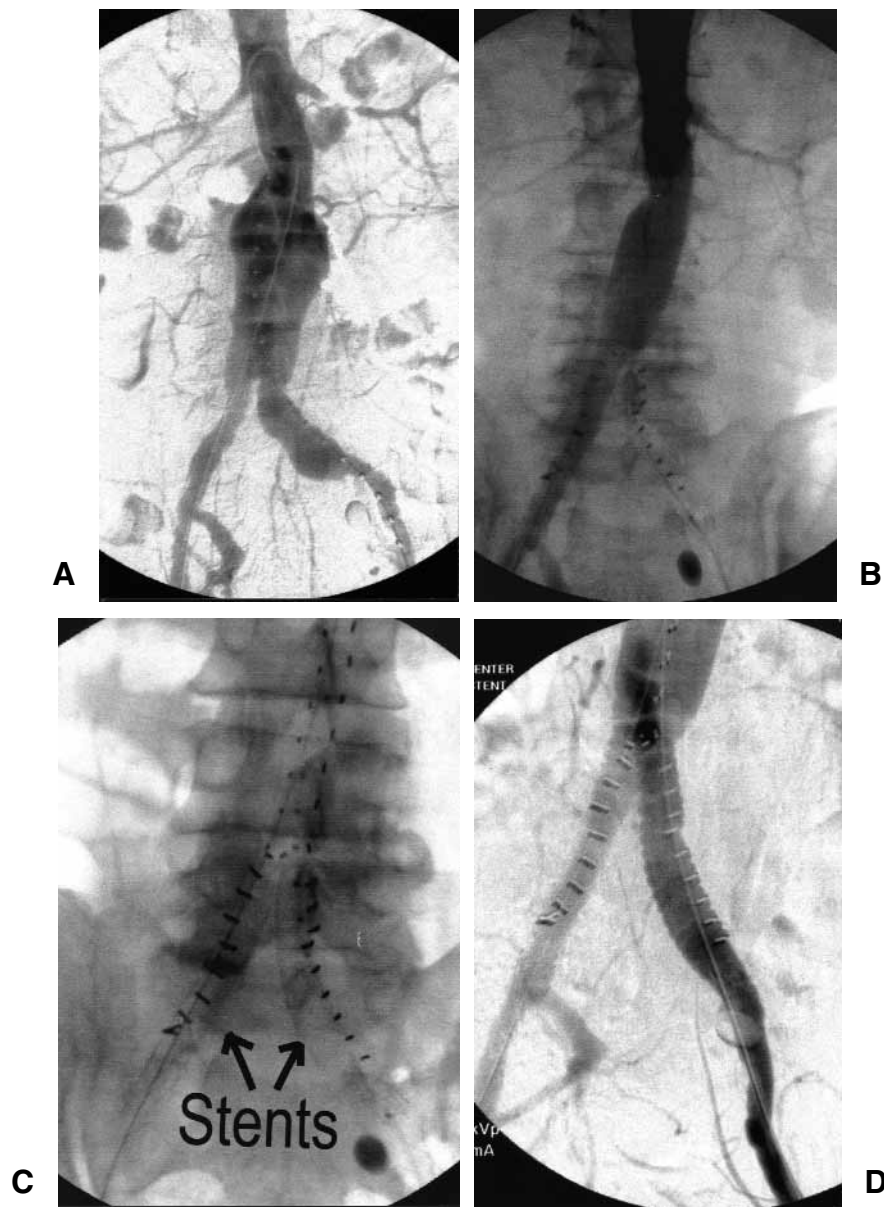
Assisted primary patency with stenting of unsupported graft limbs intraoperatively. A, Intraoperative arteriogram performed with a marker catheter (1-cm calibrations) before unsupported graft deployment shows the aortic and left common iliac artery aneurysms. After uneventful graft deployment, a completion arteriogram (B) shows no flow into the left limb of the bifurcated graft (note presence of embolization balloon previously placed in left hypogastric artery). Placement of a Wallstent (14 × 40 mm) into left limb restored its patency but caused right limb to fail by compressing it at aortic bifurcation; thus both limbs were fully stented (plain x-ray film showing stents in limbs [C]) to obtain assisted primary patency (final arteriogram [D]).
